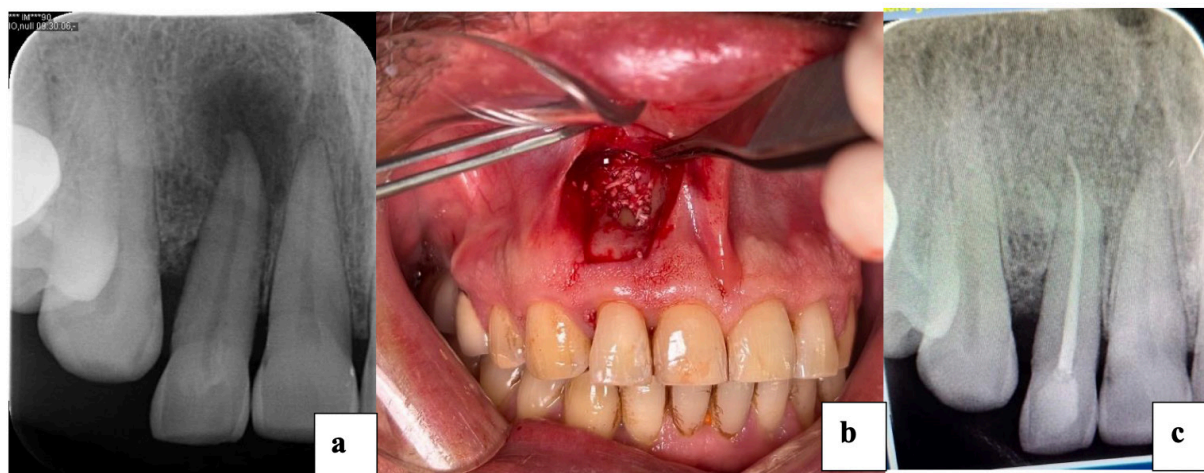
Preoperative panoramic radiograph (a) shows the periapical lesion associated with tooth #12, intraoperative view during apical surgery (b) demonstrates the allograft material in the surgical field, and postoperative periapical radiograph (c) is the 6-month periapical radiograph in Case 4.
